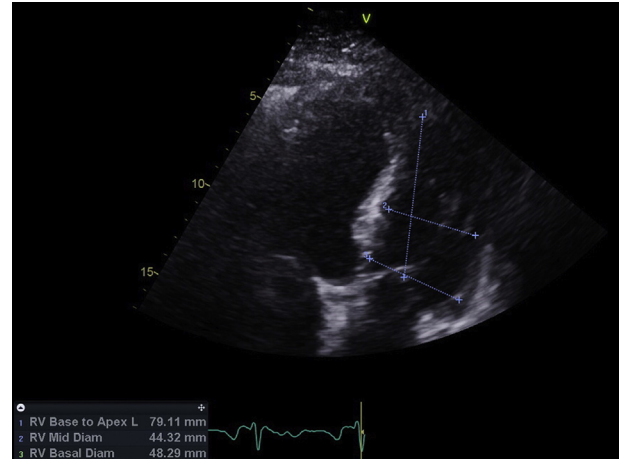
Right ventricle (RV)-focused apical four-chamber view demonstrates mild right ventricular dilatation on admission echocardiogram. *Diam*, Diameter; *L*, length.
